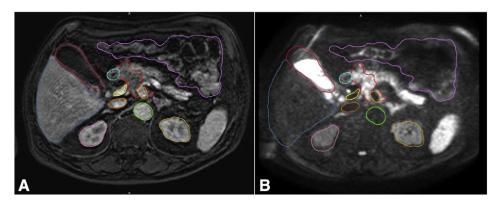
Contouring of an unresectable pancreatic tumor in the pancreatic head on arterial T1-weighted (A), and DWI (b-value 800 s/mm²) (B). Red: GTV, turquoise: duodenum, blue: liver, pink: right kidney, orange: left kidney, red: gall bladder, bright green: aorta, violet: bowel loops, orange: celiac axis, yellow: portal vein, red-orange: inferior vena cava. (Color version of figure is available online.)
